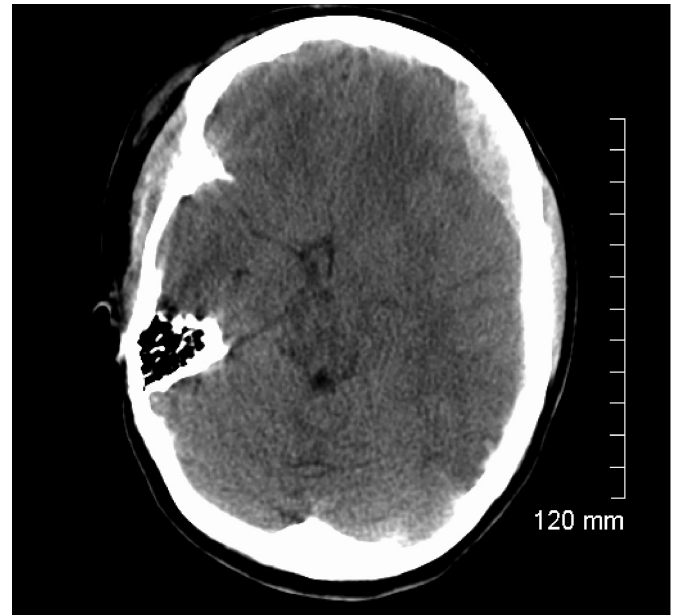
Axial soft-tissue windowed CT scan at time of presentation demonstrates the right sided extracranial soft-tissue injury with associated left sided epidural hematoma.
